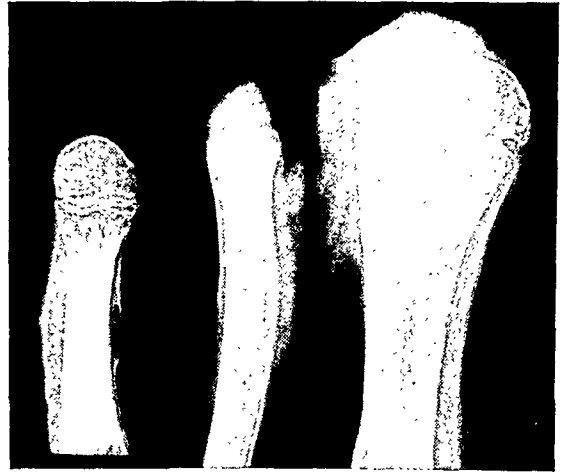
X-ray of metacarpal, rib, and upper end of fibula. The inner marrow cavity, the cortex, the outer concentric marrow cavity, and new dense bone are well shown.
